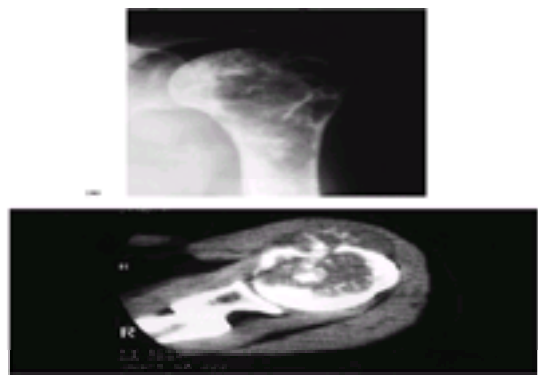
Chondrosarcoma. (a) On this plain radiograph of the proximal humerus there is a destructive lesion within the humeral head and metaphysis; there are small, punctate calcifications present suggestive of calcified cartilage. (b) On the CT scan of this lesion the calcifications are clearly seen and an extrasosseous component can be appreciated.
